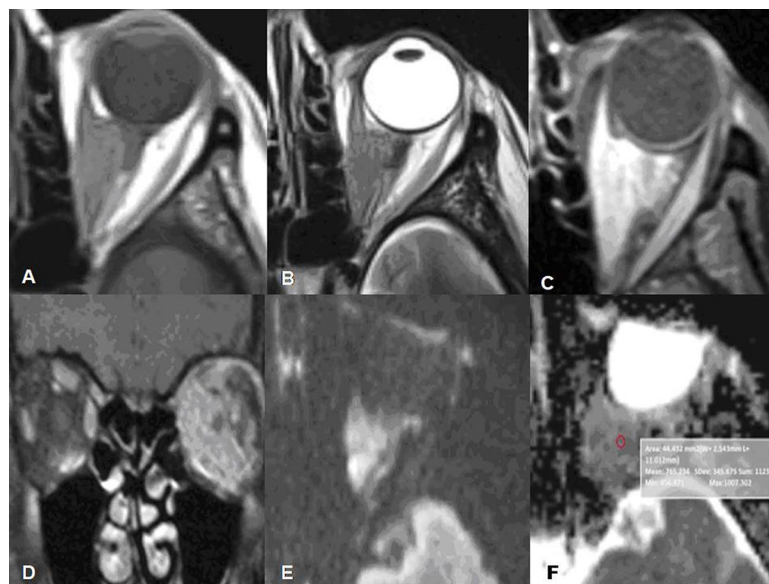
A 56-year-old female patient with long history of left-sided dull aching orbital pain, chronic visual loss of left eye and limited left orbital movement. Axial T1 A shows T1 hypointense infiltrative retrobulbar mass involving the left medial rectus muscle, as well as the related extraconal and intraconal fat planes and encasing the optic nerve. Axial T2 image B shows ill-defined T2 hypointensity of the lesion. Axial and coronal T1 post-contrast images (C and D) reveal homogeneous enhancement of the mass lesion. Evident diffusion restriction on DWI (b_{1000})/ADC (E, F). The ADC value is $0.76 \times 10^{-3} \text{ mm}^2/\text{sec}$ (F). Pathologically proved left-sided retrobulbar lymphoma (NHL) encasing the left optic nerve
